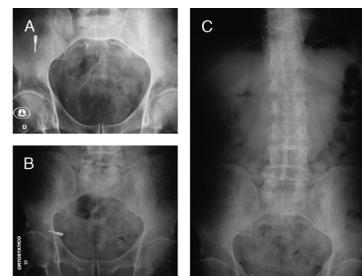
Anteroposterior abdomen and pelvis radiographs: 1 (A), 3 (B), and 5 (C) days.
